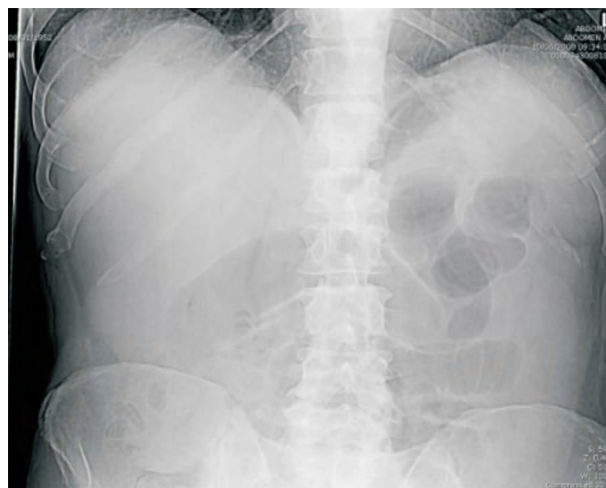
X-ray abdomen supine showed dilated small-bowel loops.
